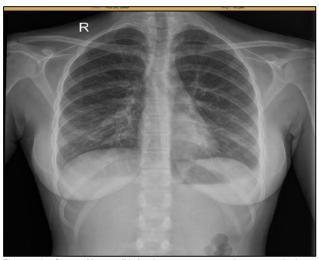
Chest X-ray: Right lower zone patchy ground-glass opacity
